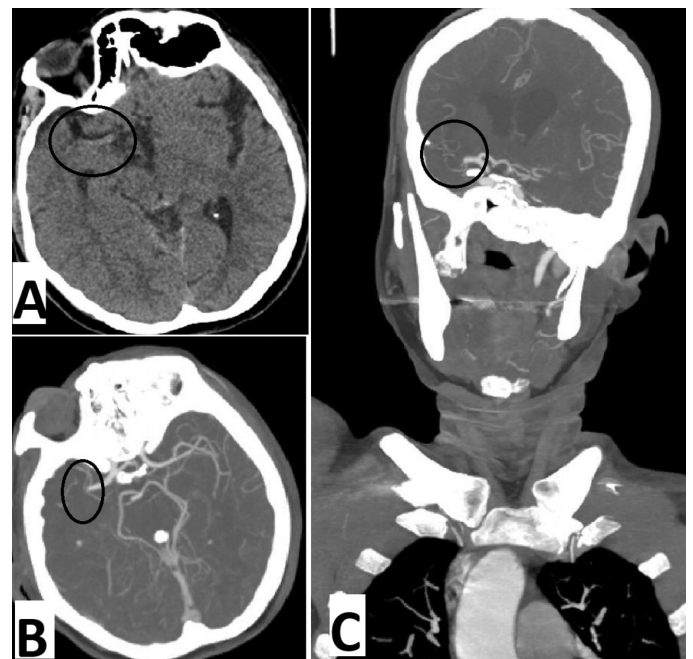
(A) Non-contrast CT imaging of the patient: hyperdense artery sign in the right MCA. (B) Axial image and (C) coronal image CT angiography. The right MCA was observed to be occluded after the level where the anterior temporal artery
